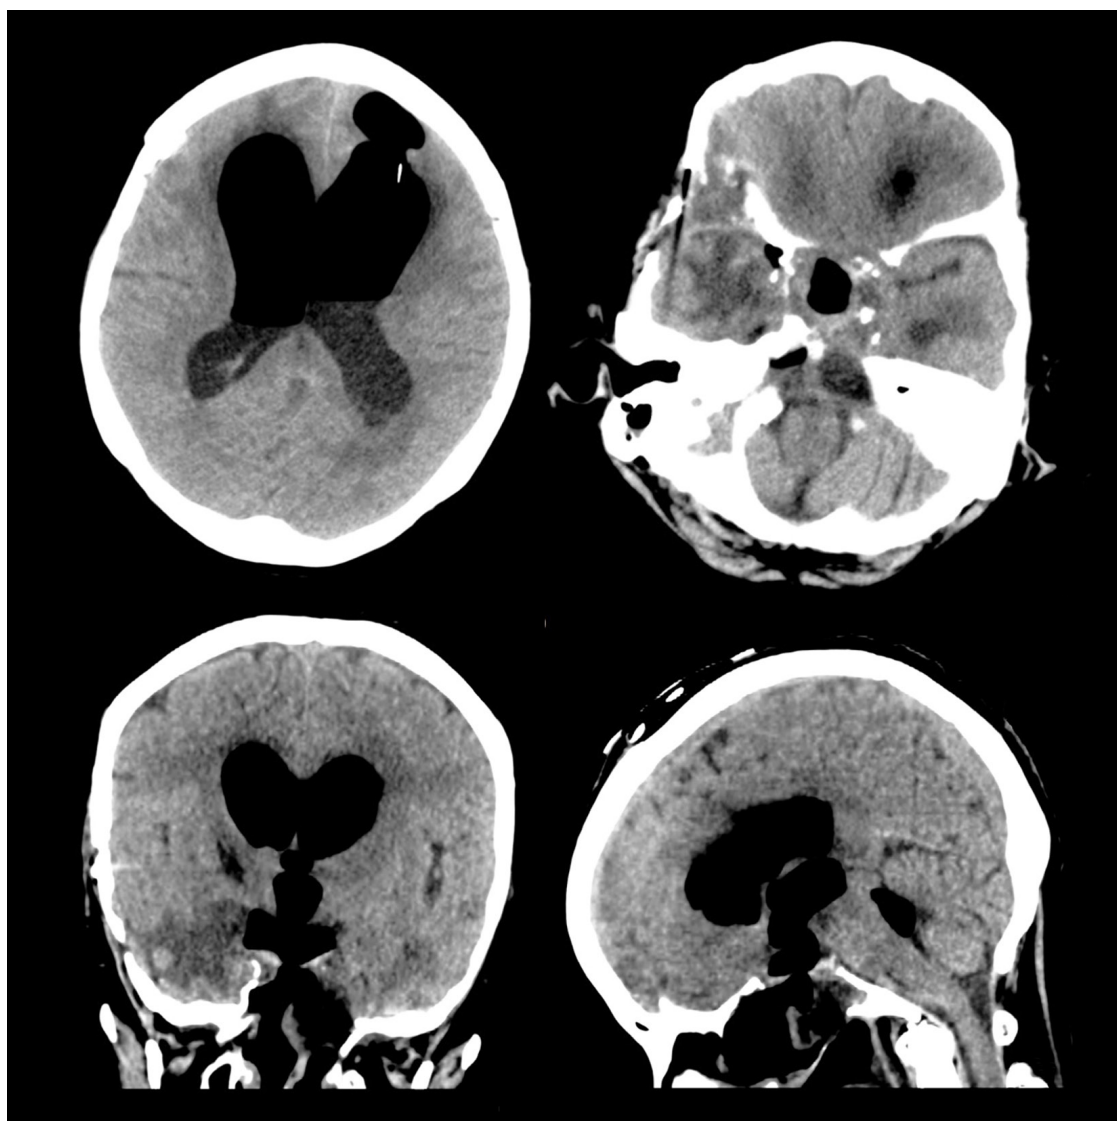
Brain computed tomography image 3 days after the additional endoscopic irrigation. Severe pneumocephalus and hydrocephalus with flap defect are observed.
